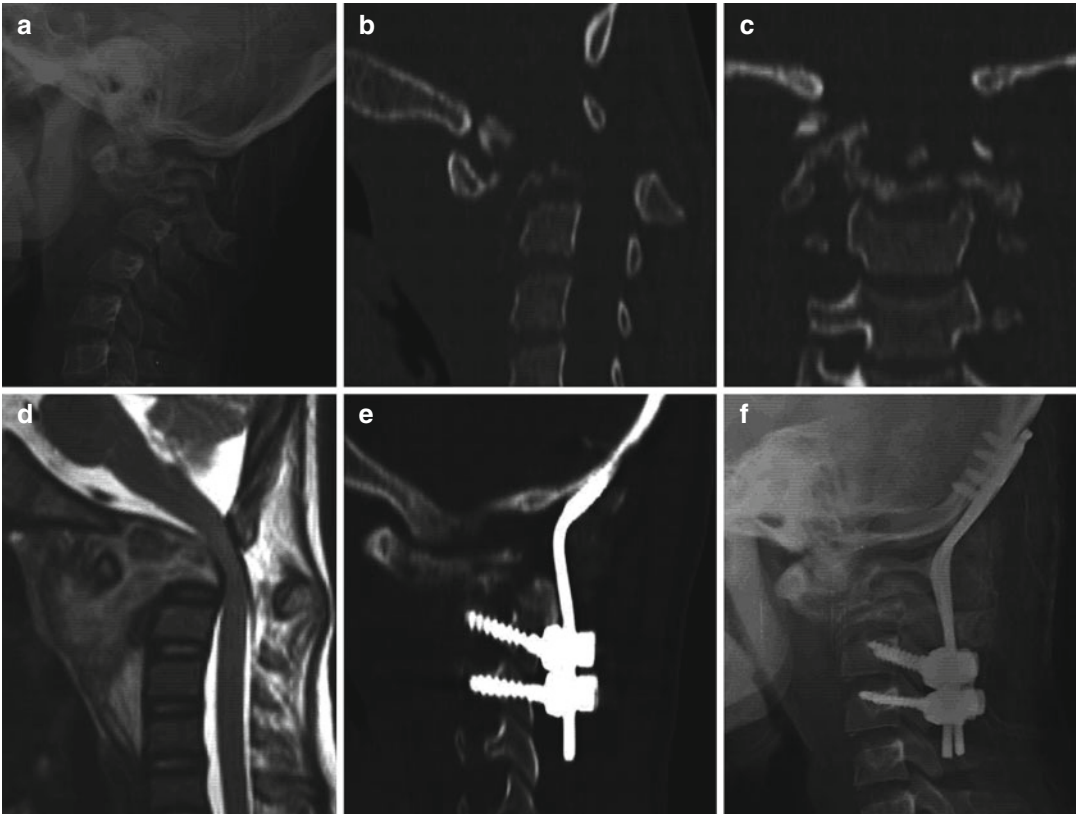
A 13-year-old child presented with upper cervical tuberculosis. The lateral radiograph (a), sagittal and coronal CT (b, c) shows the complete destruction of C1 and C2 vertebrae with atlanto-axial instability and dislocation. The sagittal MR image shows extensive prevertebral abscess formation and cord compression at the level of C1
